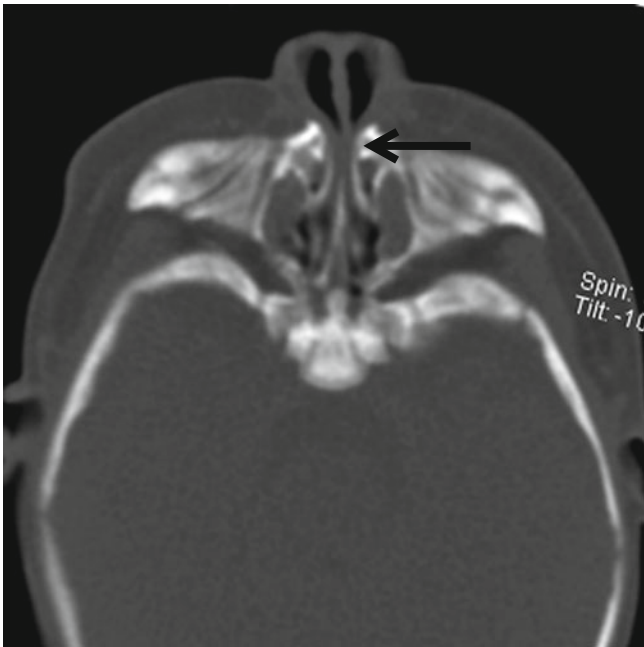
Pyriform aperture stenosis in a 1-month-old infant. Axial CT scan shows inward bowing of the nasal process of the maxilla and narrowing of the anterior nasal cavity (*arrow*)
